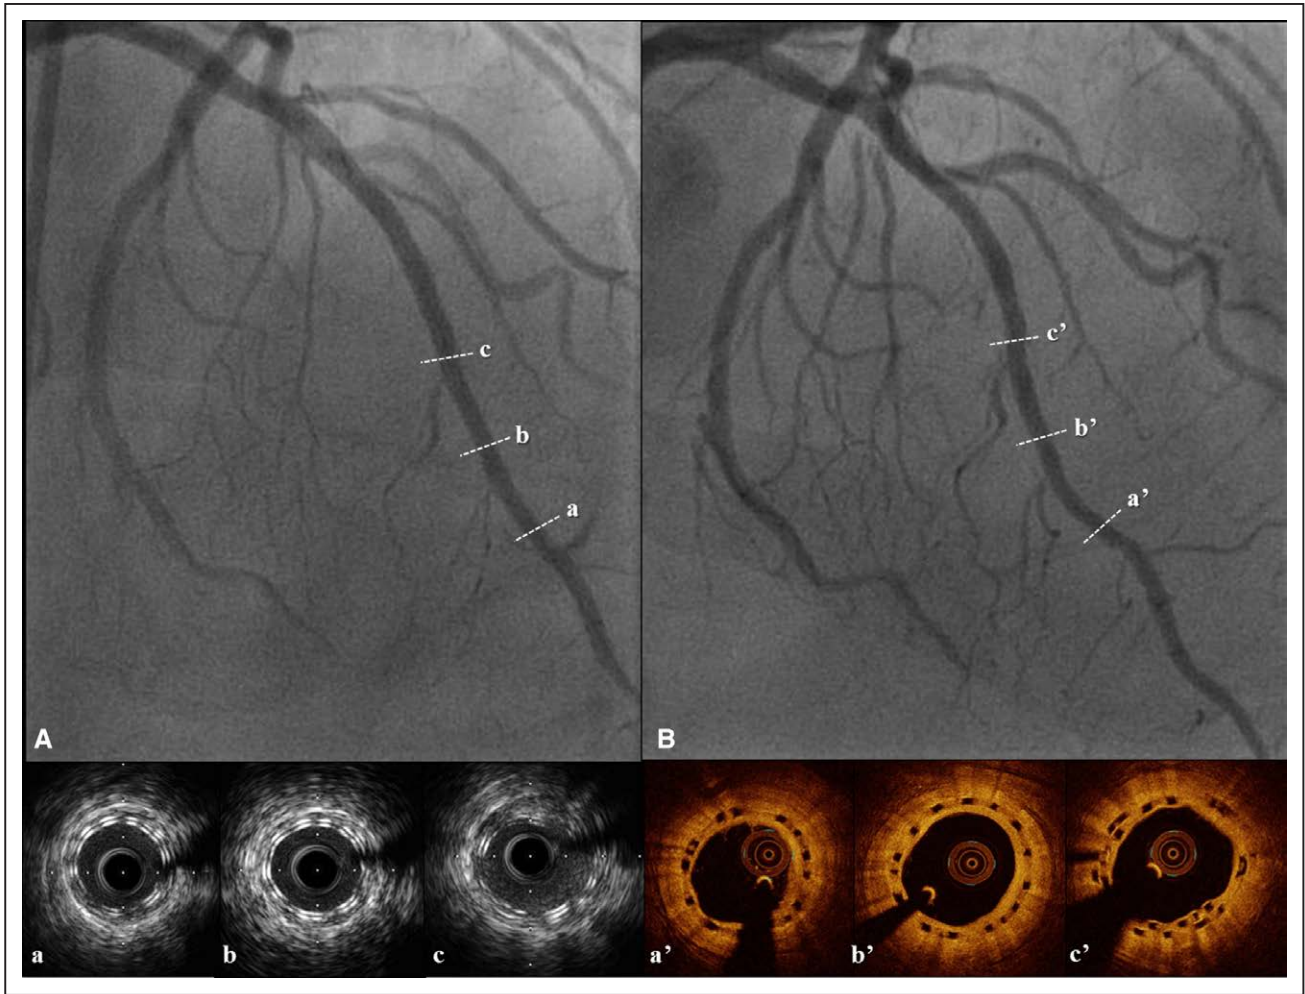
Angiographic and intravascular images after BVS implantation for LAD CTO at initial PCI and 18-month follow-up (the same case in Figure 1). A, Angiography after revascularization for LAD CTO with BVS. a–c, Short-axial views of IVUS images at each of the lesions indicated with white dashed line in Figure 2A. B, Angiography at 18-month follow-up of LAD CTO treated with BVS. a'–c', Short-axial views of OCT images at each of the lesions indicated with a white dashed line in Figure 2B. BVS indicates bioresorbable vascular scaffold; CTO, chronic total occlusion; IVUS, intravascular ultrasound; LAD, left anterior descending artery; and PCI, percutaneous coronary intervention.
